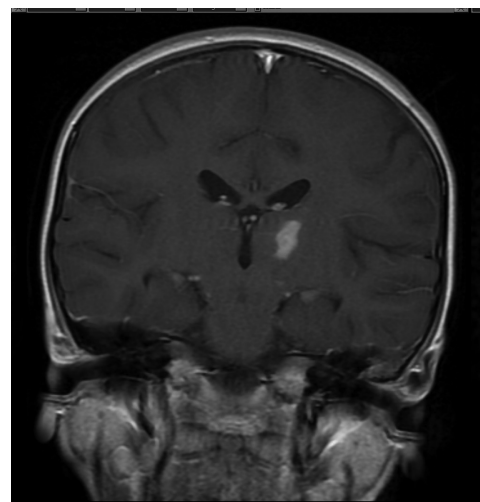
Follow-up MRI of the patient (1 month after the onset of symptoms) shows resolving of the previously described area (on coronal T2-weight image).
